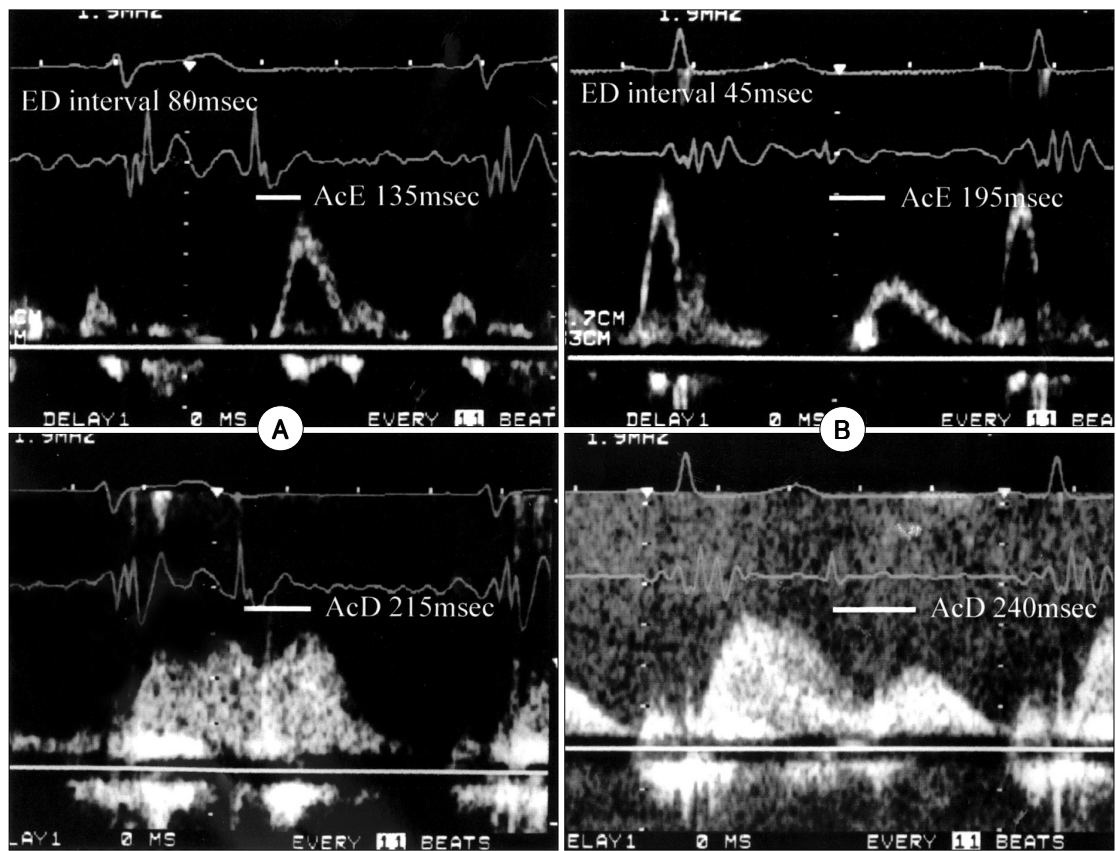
Method of measurement of time interval from the peak of E wave to the peak of D wave (ED interval). Time interval from aortic valve closure to the peak of E wave (AcE) and time interval from aortic valve closure to the peak of D wave (AcD) were measured with phonography and pulsed-wave doppler. ED interval was calculated by the subtraction of AcE from AcD. A : ED interval in patient with E/A ≥ 1 . B : ED interval in patient with E/A < 1 .
